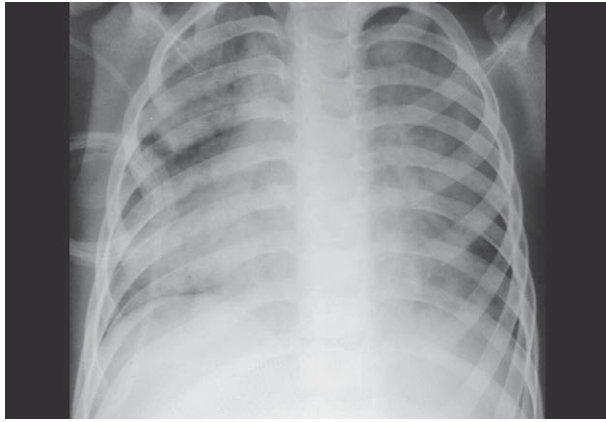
Chest x-ray demonstrating bilateral severe diffuse infiltrates consistent with acute respiratory distress syndrome.
